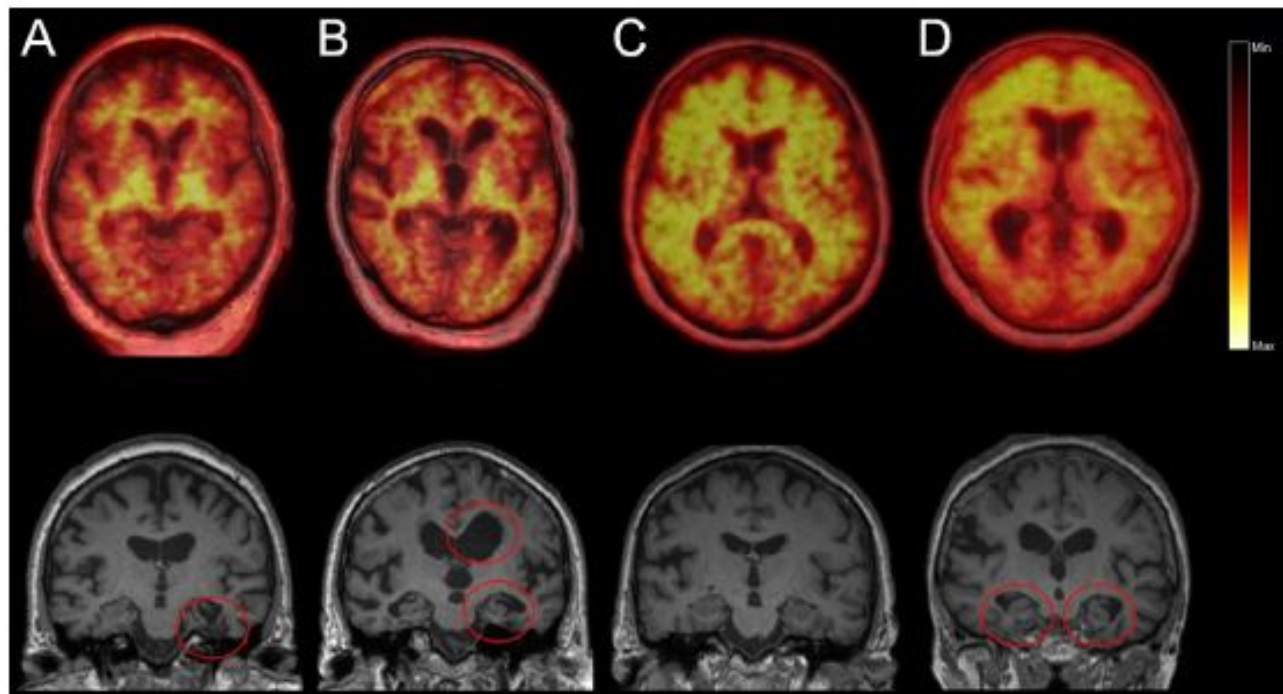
DIFFERENT IMAGIOLOGICAL PATTERNS IN PATIENTS WITH LOW COGNITIVE DEFICIENCY THROUGH PET-MRI STUDIES WITH APPLICATION OF ^{18}F -FLORBETABEN, THE TOP LINE PRESENTS TRANSAXIAL PET-MRI IMAGES AND THE LOWER LINE CORONAL SECTIONS OF T1 IMAGES: (A) NEGATIVE PET STUDY, ILLNESS WITH TRAUMATIC CHANGES IN THE LEFT HYPOCAMP (CIRCLE) POSSIBLE INDICATION OF COGNITIVE DEFICIENCY; (B) NEGATIVE PET STUDY WITH HYPOCAMP ATROPHY (CIRCLES) AND SUBCORTICAL ASYMMETRY OF FRONTOTEMPORAL DEMENTIA; (C) PET POSITIVE STUDY, PATIENT WITH NO ATROPHY VISIBLE ON MRI IMAGE WITH POSSIBLE INTERMEDIATE AD LEVEL; AND (D) POSITIVE, PATIENT PET STUDY WITH VISIBLE ATROPHY ON MRI IMAGE WITH POSSIBLE AD LEVEL (NOTE: LEFT BRAIN APPEARS AT RIGHT) [14]
